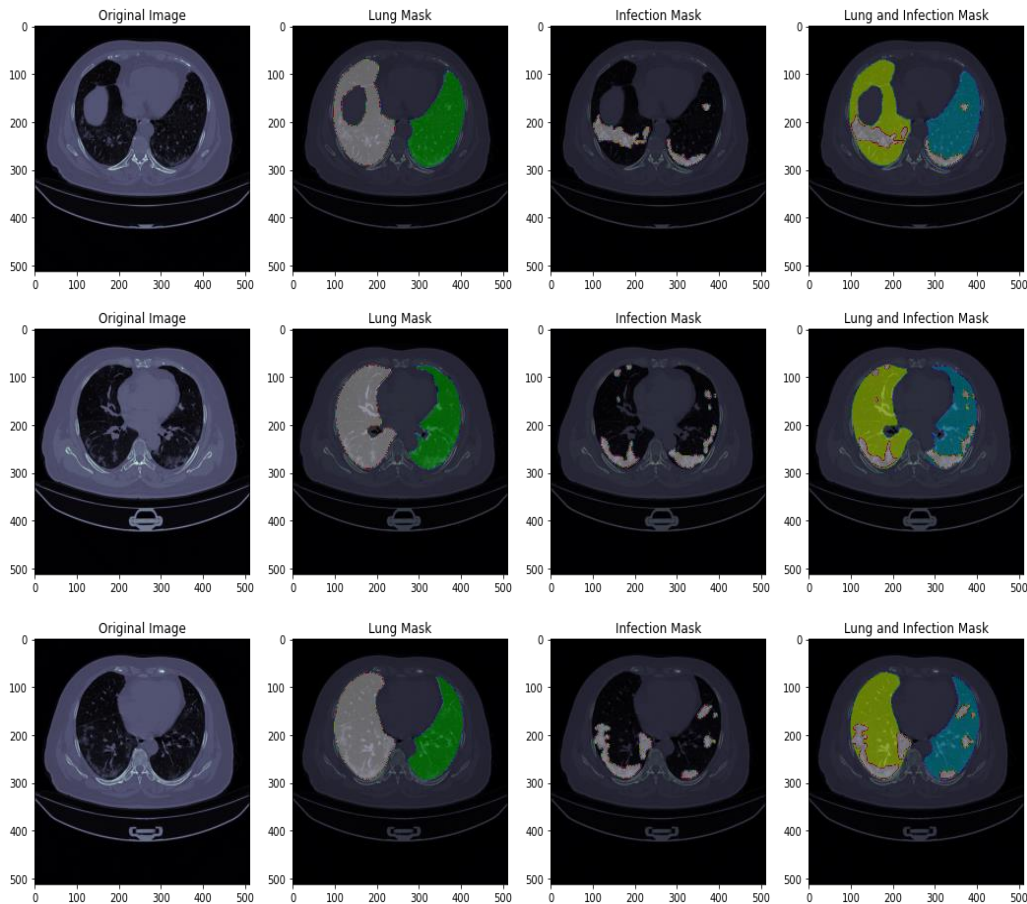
Visualization of random samples of CT scan (axial view) and the corresponding label.
